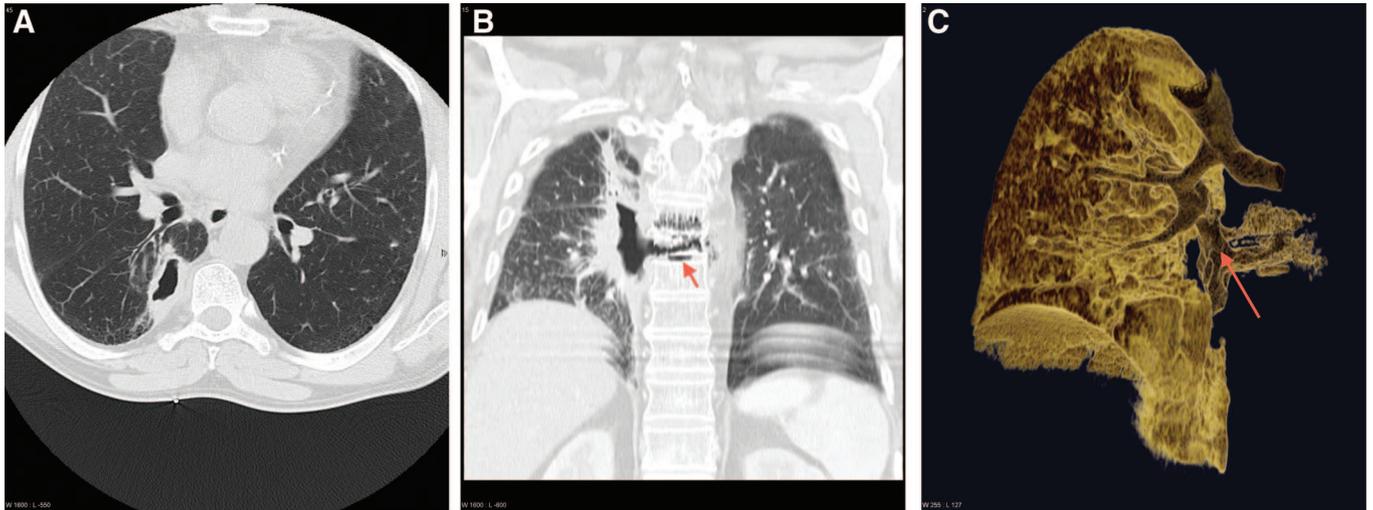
Thoracic computed tomography (CT) at initial diagnosis. *A*, Axial image, lung windows. A cavitating lesion abuts the pleura in the apical segment of the right lower lobe consistent with primary squamous cell lung carcinoma. Thoracic CT at representation. *B*, Coronal image, lung windows. Further cavitation with fistulous communication with the T6 and T7 vertebra and adjacent intervertebral disc spaces (red arrow). *C*, 3D reconstruction. A gas-filled tract (red arrow) extends from the right main bronchus via the cavity into the thoracic vertebral bodies and disc spaces.
